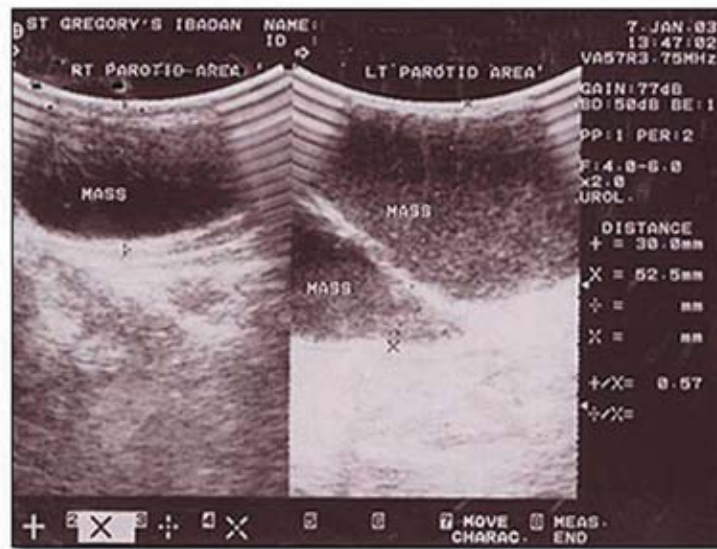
Ultrasound picture of salivary gland lesion showing hypochoic cystic areas.
